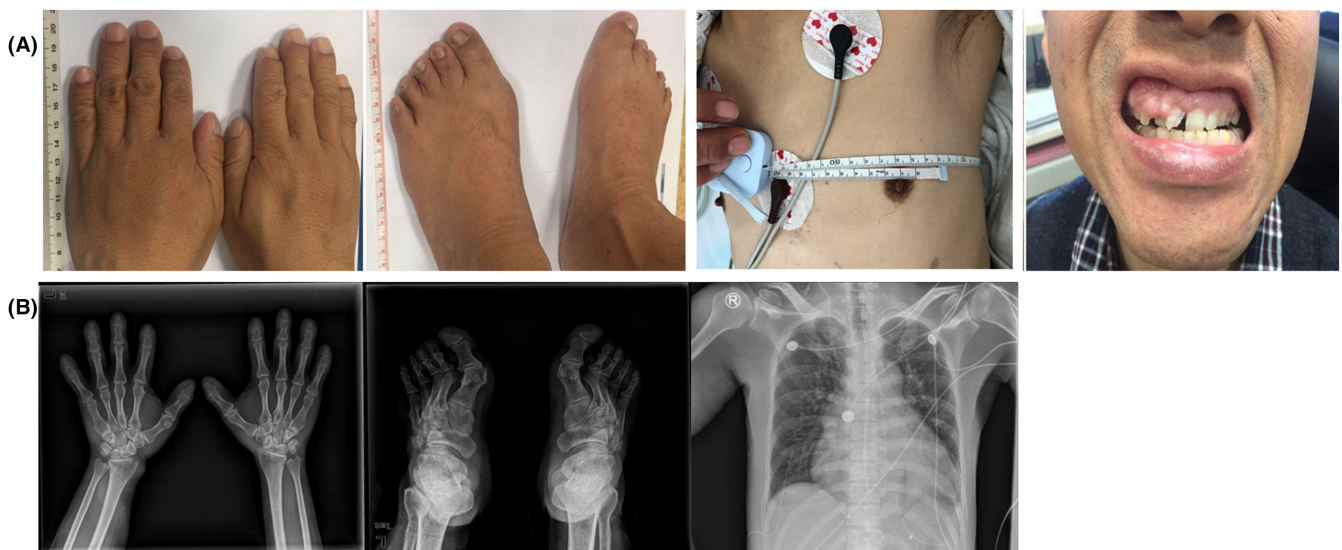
Clinical and radiological features of the JATD proband. (A) The proband manifested with a small chest, short extremities with short fingers and toes, and deformity teeth. (B) X-rays of the proband show shortening of the ribs, fingers and toes.
